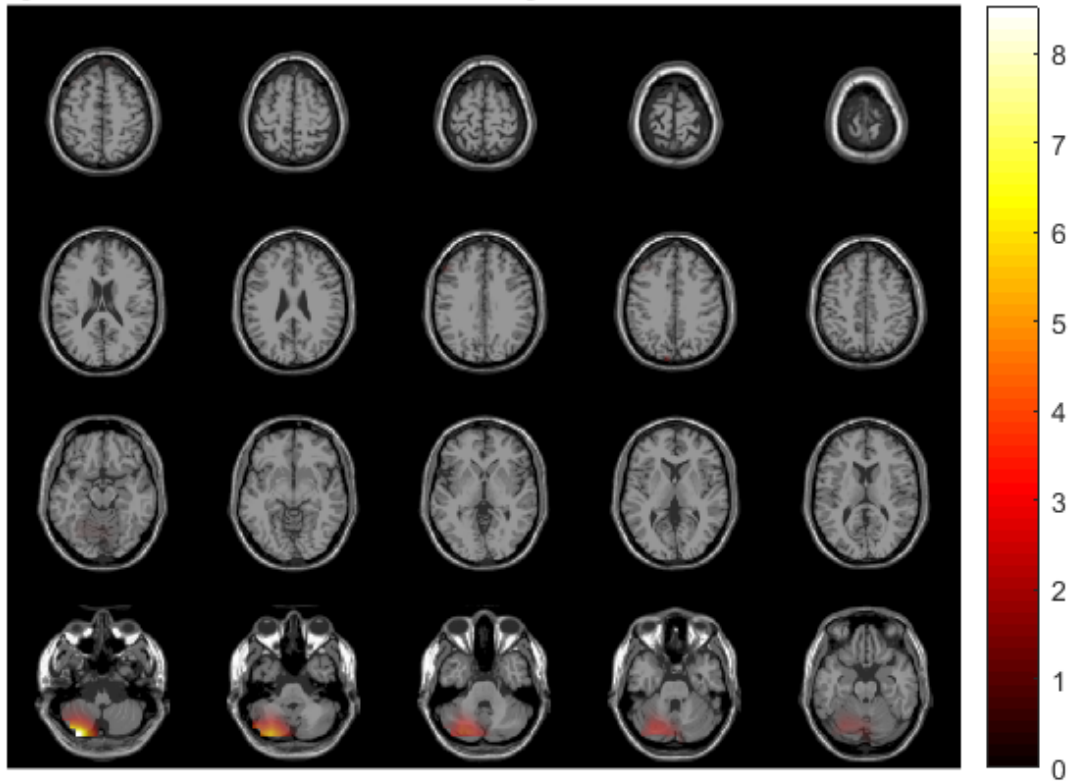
MRI Contrast Plot developed by subtracting the lowest ruminating participant's (Participant #1132) average power from the highest ruminating participant's (Participant #1134) average power to determine the areas specific to low ruminators. Within this plot, the areas in yellow indicate higher activation and the areas in red indicate lower activation.
